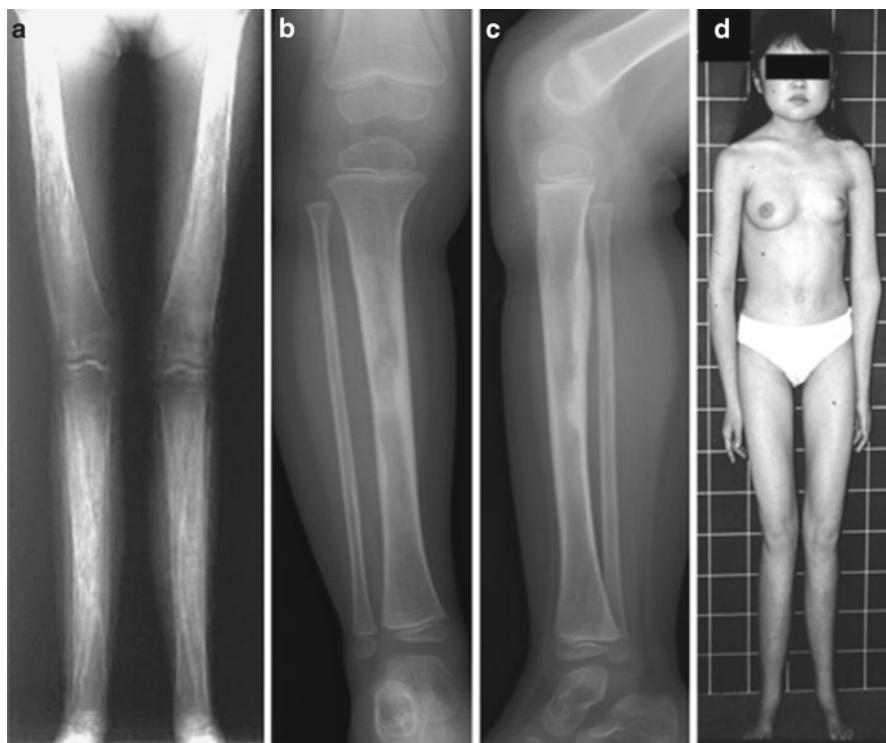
Clinical features of Engelmann disease. (a) radiographs of the lower extremities in the late stage bone changes of the Engelmann disease. Symmetric hyperossification of the long bones. Bone widths and bone densities are increased, showing that both exo- and endo-osteal bone formation are increased. (b, c) the *right* leg A-P (b) and lateral (c) radiographs showing the early stage bone changes of disease. Irregular thickening of the cortex of tibial diaphysis. (d) marfanoid habitus (slender and relatively long limbs) of a patient
